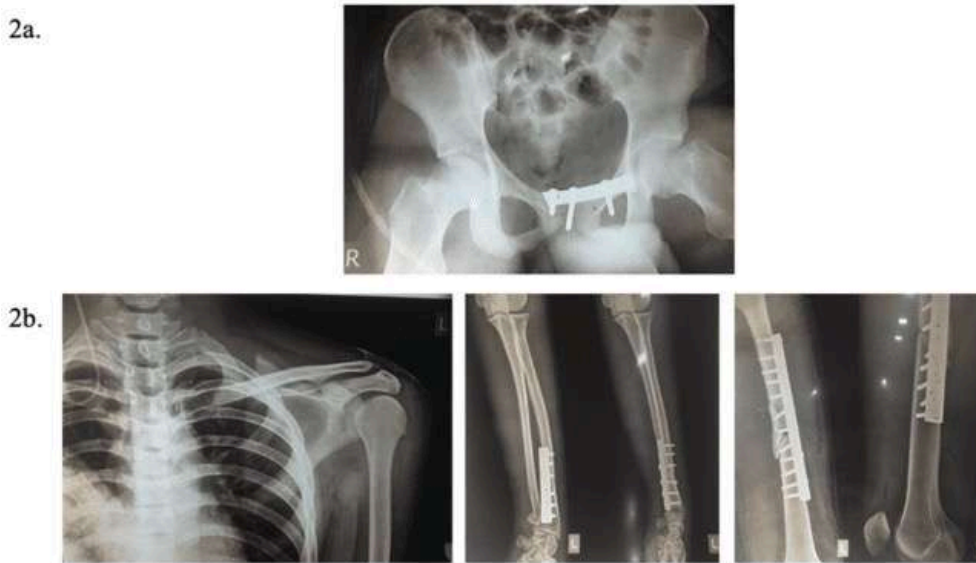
2a) Plain X-Ray film after the first surgery showing a plate and screw was placed on the superior of pubic ramus. 2b) After Damage Control Orthopedic Shoulder dislocation was reduced, plate and screw were placed on the distal of the radial bone and left shaft femur.
